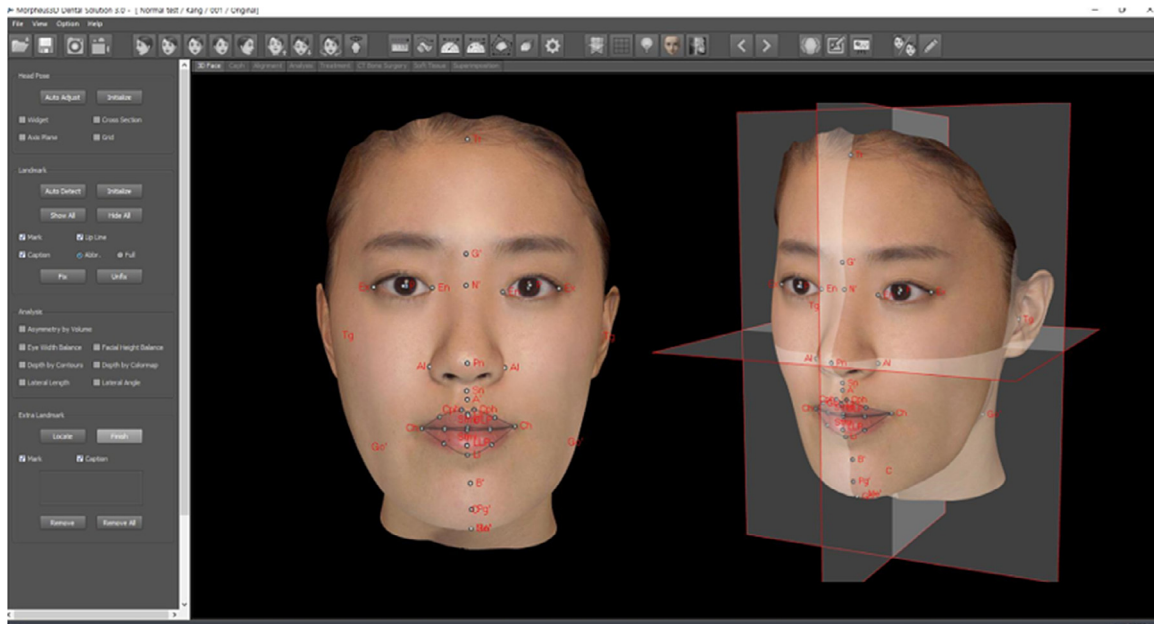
3D landmark autodetection using Morpheus3D Scanner and CT software (Morpheus, Seoul, Korea).
